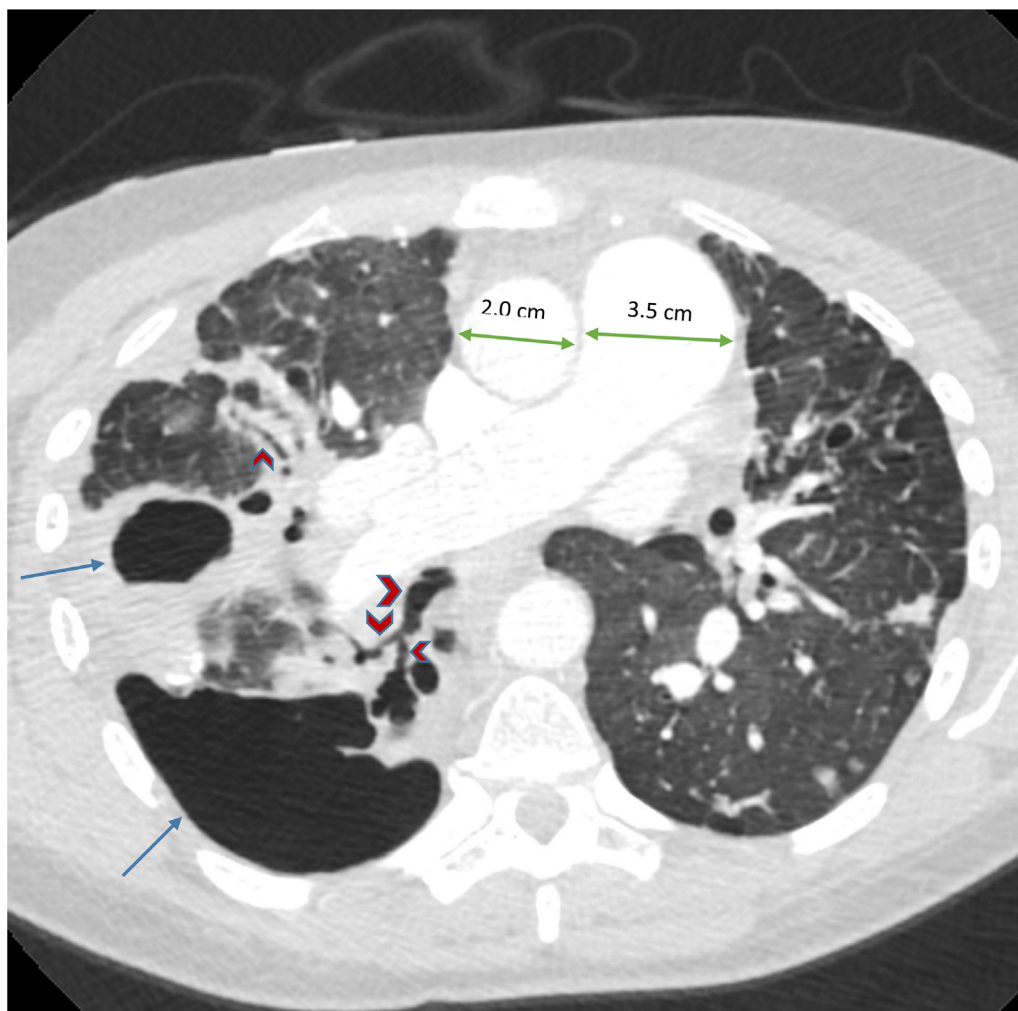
An axial image of a CTA chest for pulmonary emboli displayed in the lung window. Extensive emphysematous changes bilaterally with multiple prominent pulmonary bullae (blue arrows), the largest within the posterior right lobe. There are multiple associated regions of bronchiectasis (red arrowheads) and bronchial wall thickening. Dilatation of the pulmonary vasculature (green arrows) is also apparent.
